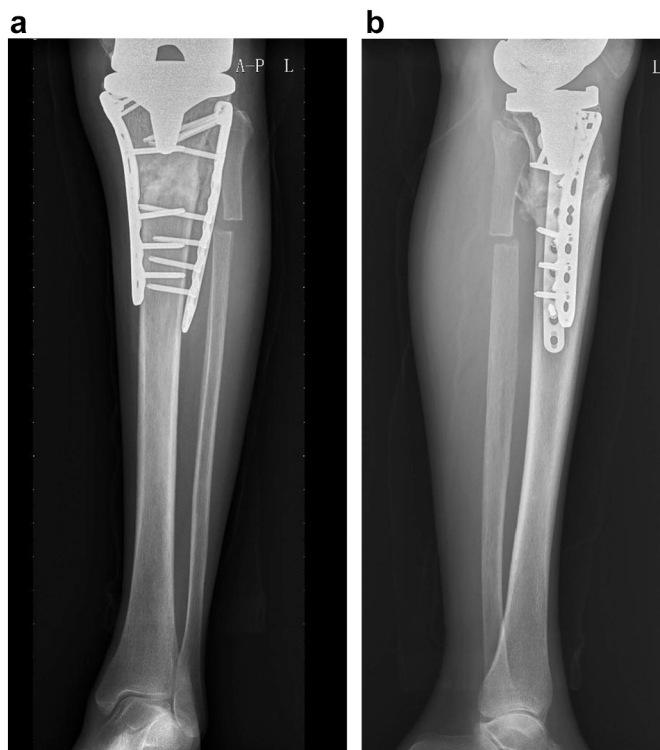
Radiographs taken 3 months after open reduction. (A) Anteroposterior view. (B) Lateral view.
